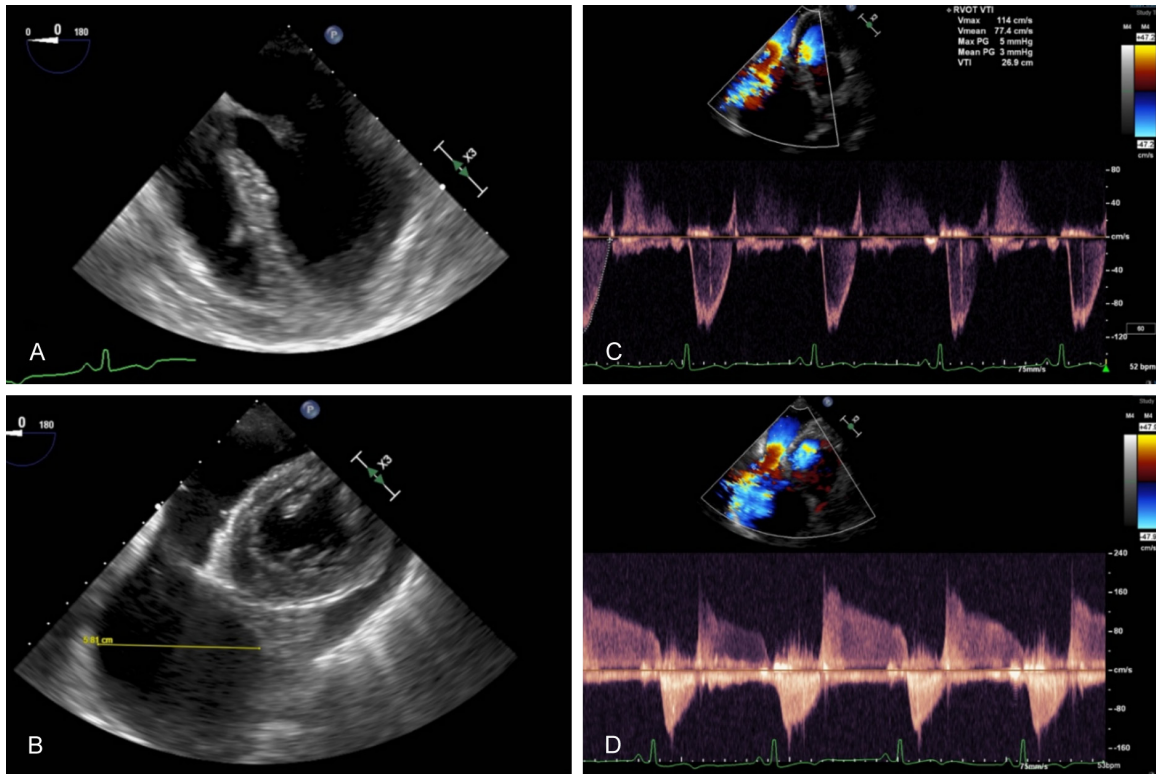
A: Transesophageal echocardiogram (TEE) showing normal left ventricular and right ventricular size. B: TEE deep gastric view showing aneurysmal main pulmonary artery measuring up to 5.8 cm in diameter. C: Deep gastric view of the TEE showing increased flow across right ventricular outflow tract with velocity time integral (VTI) of the RVOT 26.9 cm. D: Doppler study of the RVOT showing pulmonary regurgitation without evidence of pulmonic stenosis with trans-pulmonic maximal velocity (Vmax) 1.28 m/s.
